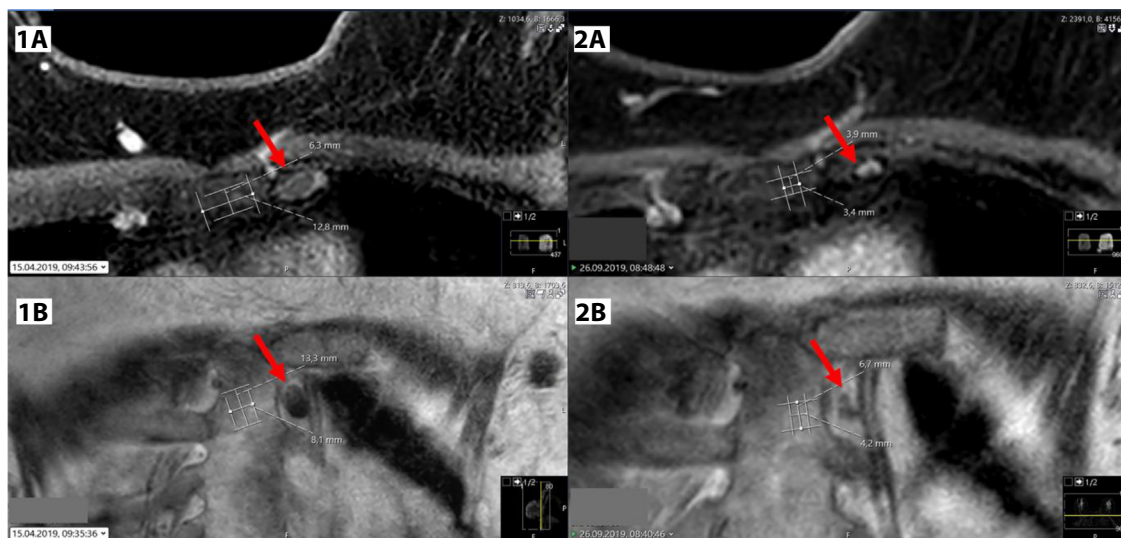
Measurement of visible IMN for response evaluation before and during/after NACT: 1-left-sided breast cancer patient with visible IMN in the left second intercostal space in axial (A) and coronal (B) planes of pretreatment MRI. 2-same patient after 5 months of NACT with clinical complete response of primary tumor and axillary metastasis and relevant decrease of the visible IMN in axial (A) and coronal (B) planes. For better clarity, measurements were placed next to the relevant lymph nodes. Red arrows indicate the internal mammary lymph nodes. *Abbreviations:* IMN = internal mammary lymph node(s); MRI = magnetic resonance imaging; NACT = neoadjuvant chemotherapy. A color version of this figure is available at [10.1016/j.ijrobp.2026.07.050].
